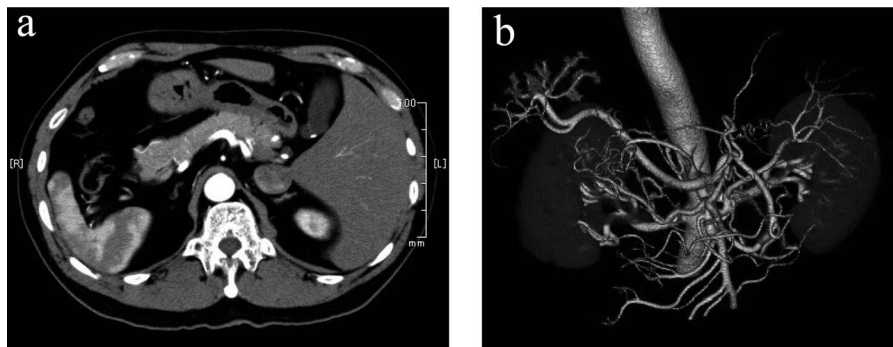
Abdominal CT. (A) CT shows that all organs inside of the abdomen were inversely positioned. (B) Left hepatic artery branched from the supramesenteric artery.
